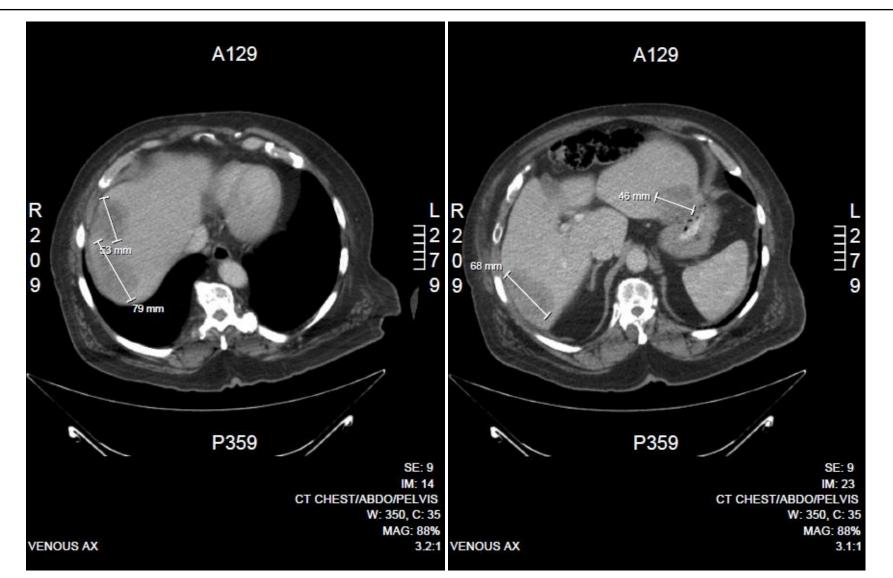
An example of RECIST performed on a CT scan of patient #1004. Dimensions were taken on the longest axis and measured in millimetres.
